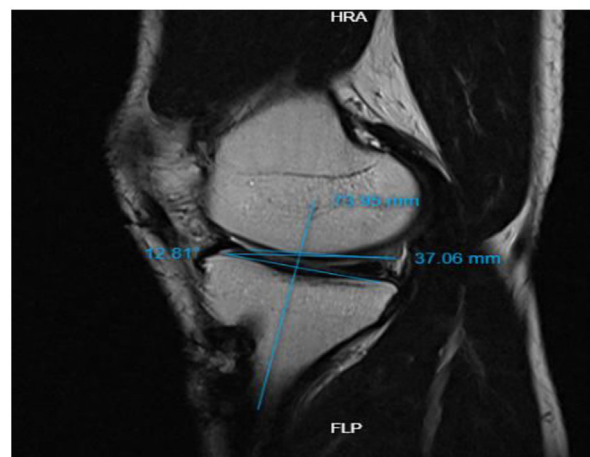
Reference lines for tibial slope measurement on sagittal MRI.
